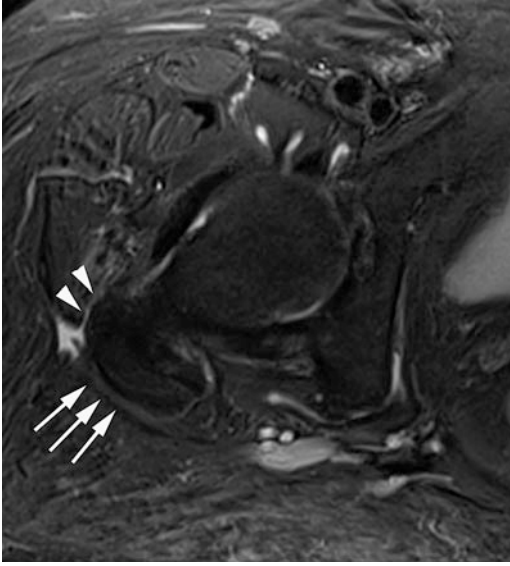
Corresponding transverse STIR image in the same patient as in Figs. 13.3 and 13.4 (TR 4,300 ms, TE 37 ms, TR 150 ms, slice thickness 6 mm). MR image shows a full thickness tear of gluteus minimus and medius tendon. The image demonstrates the missing tendon attachments. Additionally, slight peritendinous fluid is present (*white arrows* missing gluteus medius tendon attachment and *white arrowheads* missing gluteus minimus tendon attachment)
